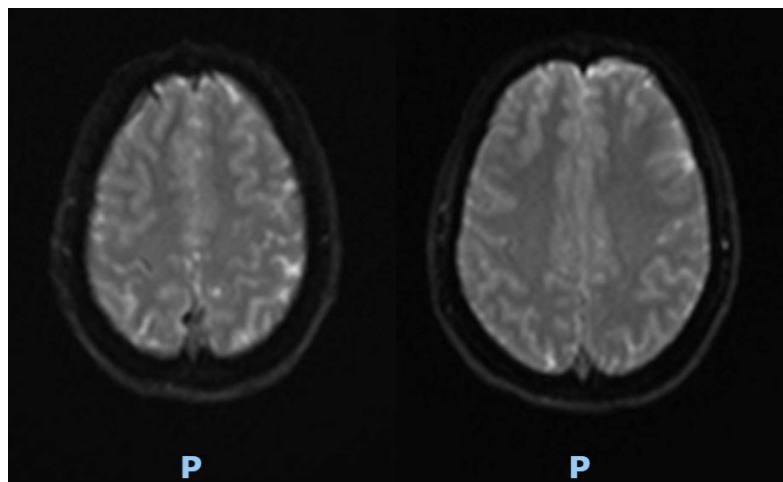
MRI Brain showing superior sagittal sinus thrombosis.
